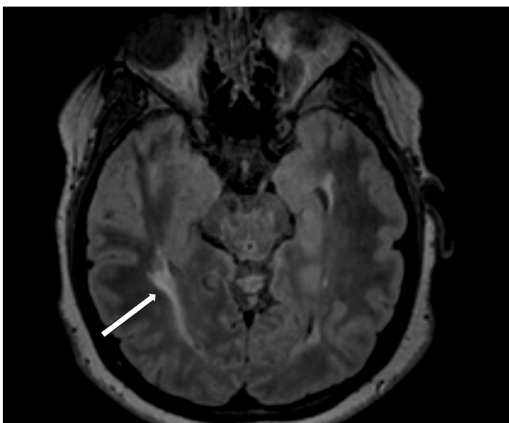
Multiple sclerosis lesions involving the optical radiations. Axial FLAIR imaging in a patient with long-standing history of multiple sclerosis, including old demyelination lesions involving the optical radiations, with an example on the right noted by a white arrow.
